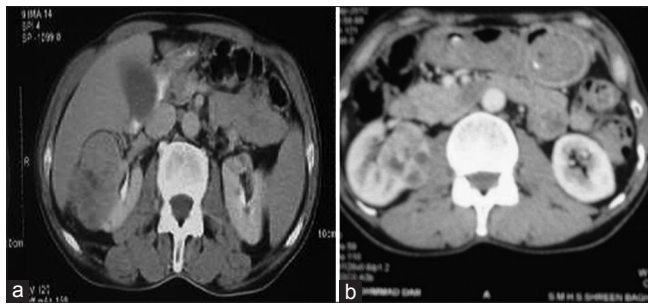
(a) Abdominal computed tomography scan with intravenous contrast showing a heterogeneous solid mass in the lateral side of right kidney. (b) Axial cuts showing well-circumscribed mass arising from right kidney
